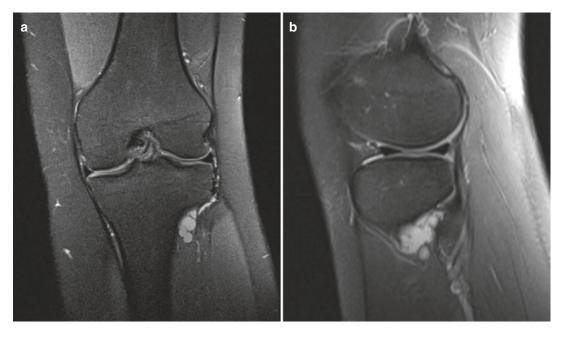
(a, b) Ganglion cysts of the proximal tibiofibular joint. (a) Coronal fat-suppressed proton density MR image; (b) sagittal fat-suppressed proton density MR image. Anterior to the proximal tibiofibular joint, there is
